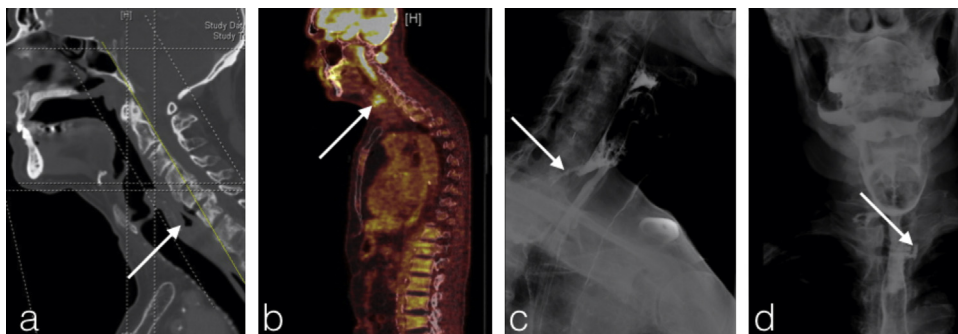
C6 pharyngoesophageal fistula in patient 5: a: sagittal cervical CT slice with C5C6 prevertebral air density; b: PET scan with hyperfixation at pharyngoesophageal junction; c: lateral esophago-gastric-duodenal transit at cervical level with additive retroesophageal image; d: esophago-gastric-duodenal transit at cervical level with contrast medium leakage.
